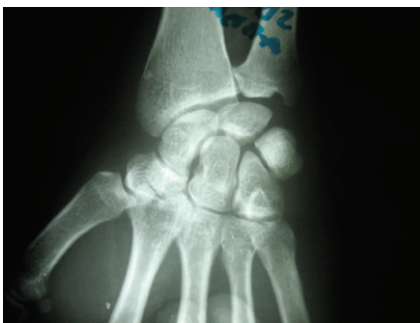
Radiograph of the wrist after closed reduction.
